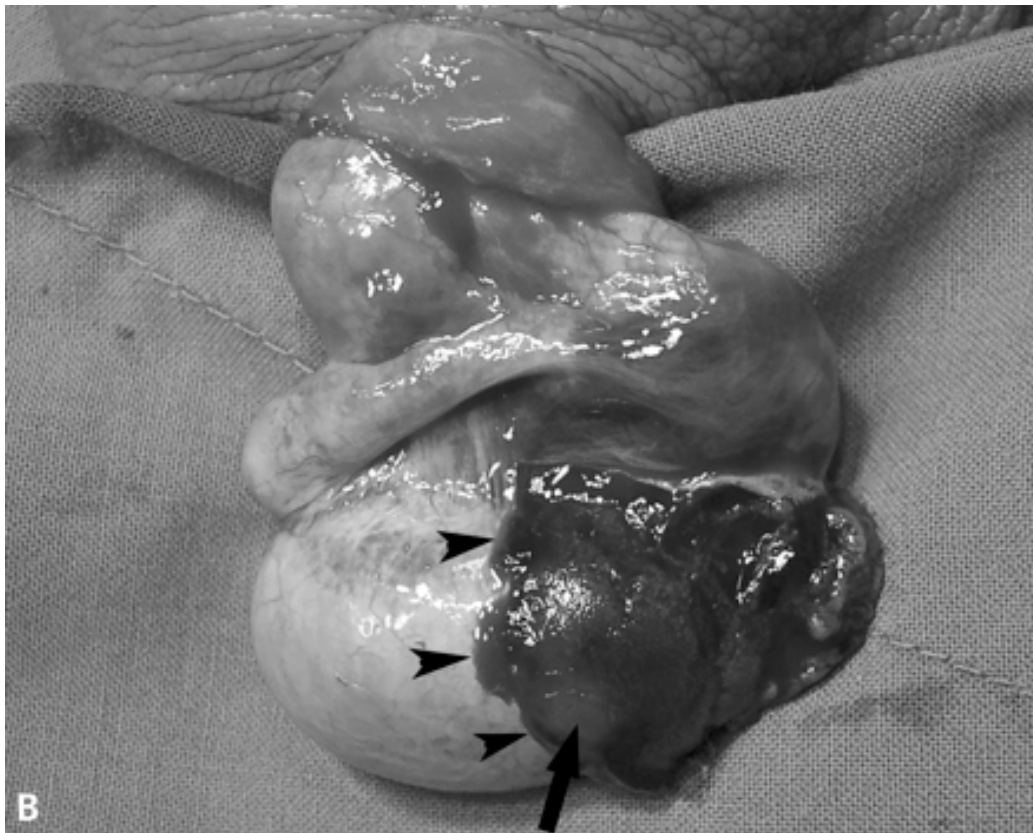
This surgical image shows what the ultrasound image in the above figure identified. There is a testicular rupture (arrowheads) with exposed seminiferous tubules (arrows). (www.jultrasoundmed.org)
